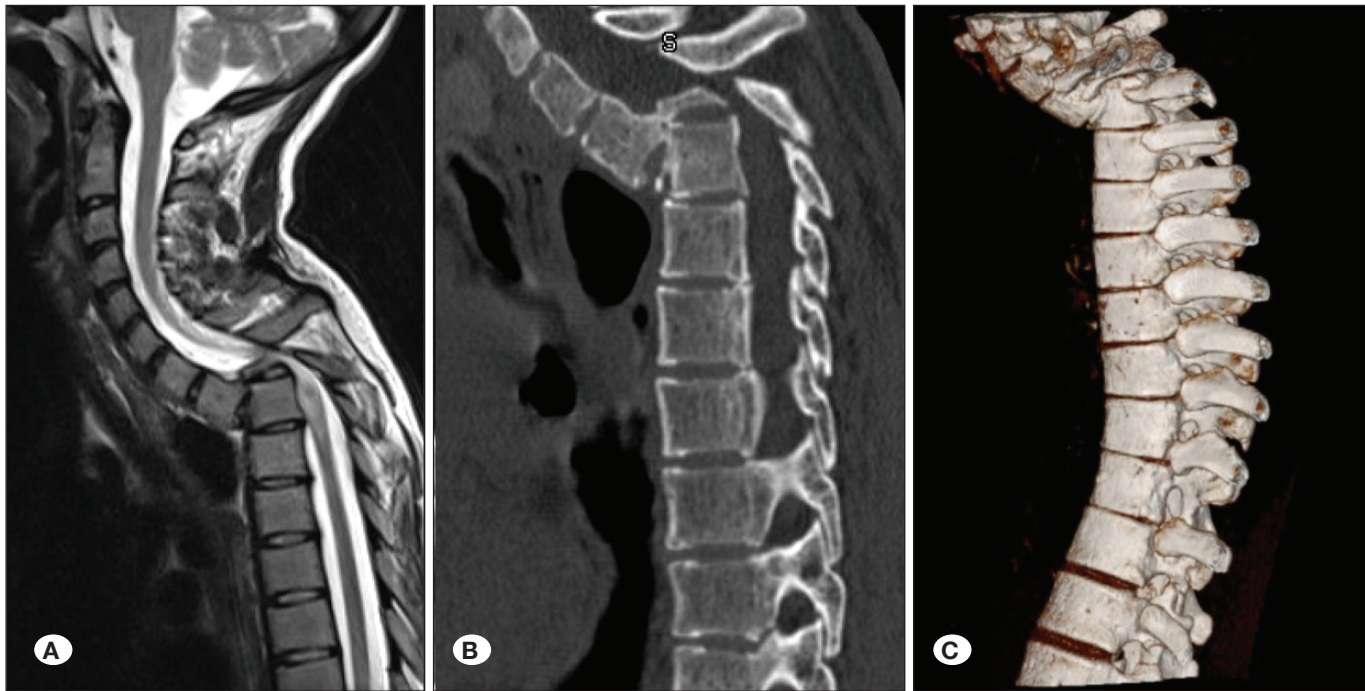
Preoperative radiological images. A) T2-sequence magnetic resonance image showing signs of myelopathy and slippage of the thoracic vertebra due to lysis of the adjacent vertebra. B) Sagittal computed tomography reconstruction showing Th2 lysis and Th1-3 spondyloptosis. C) 3D reconstruction showing severe kyphosis due to spondyloptosis following tuberculosis.
